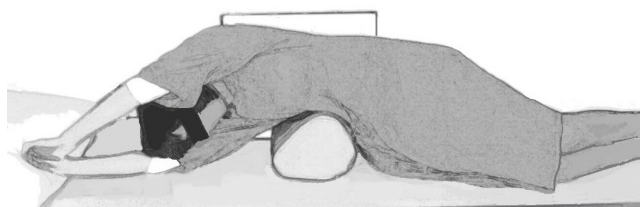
With the patient in lateral decubitus position, a fulcrum is placed at the rib corresponding to the apex of the curve. Coronal and lateral radiographs are taken with patient in this position.
